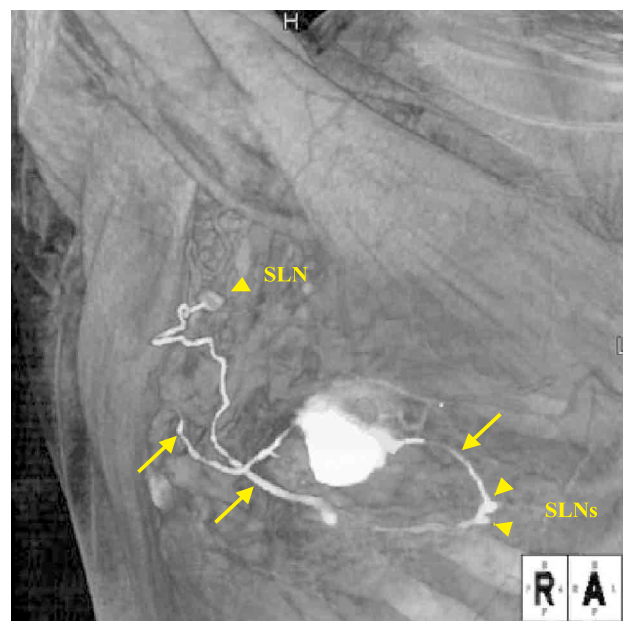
3D CT lymphography of breast cancer
